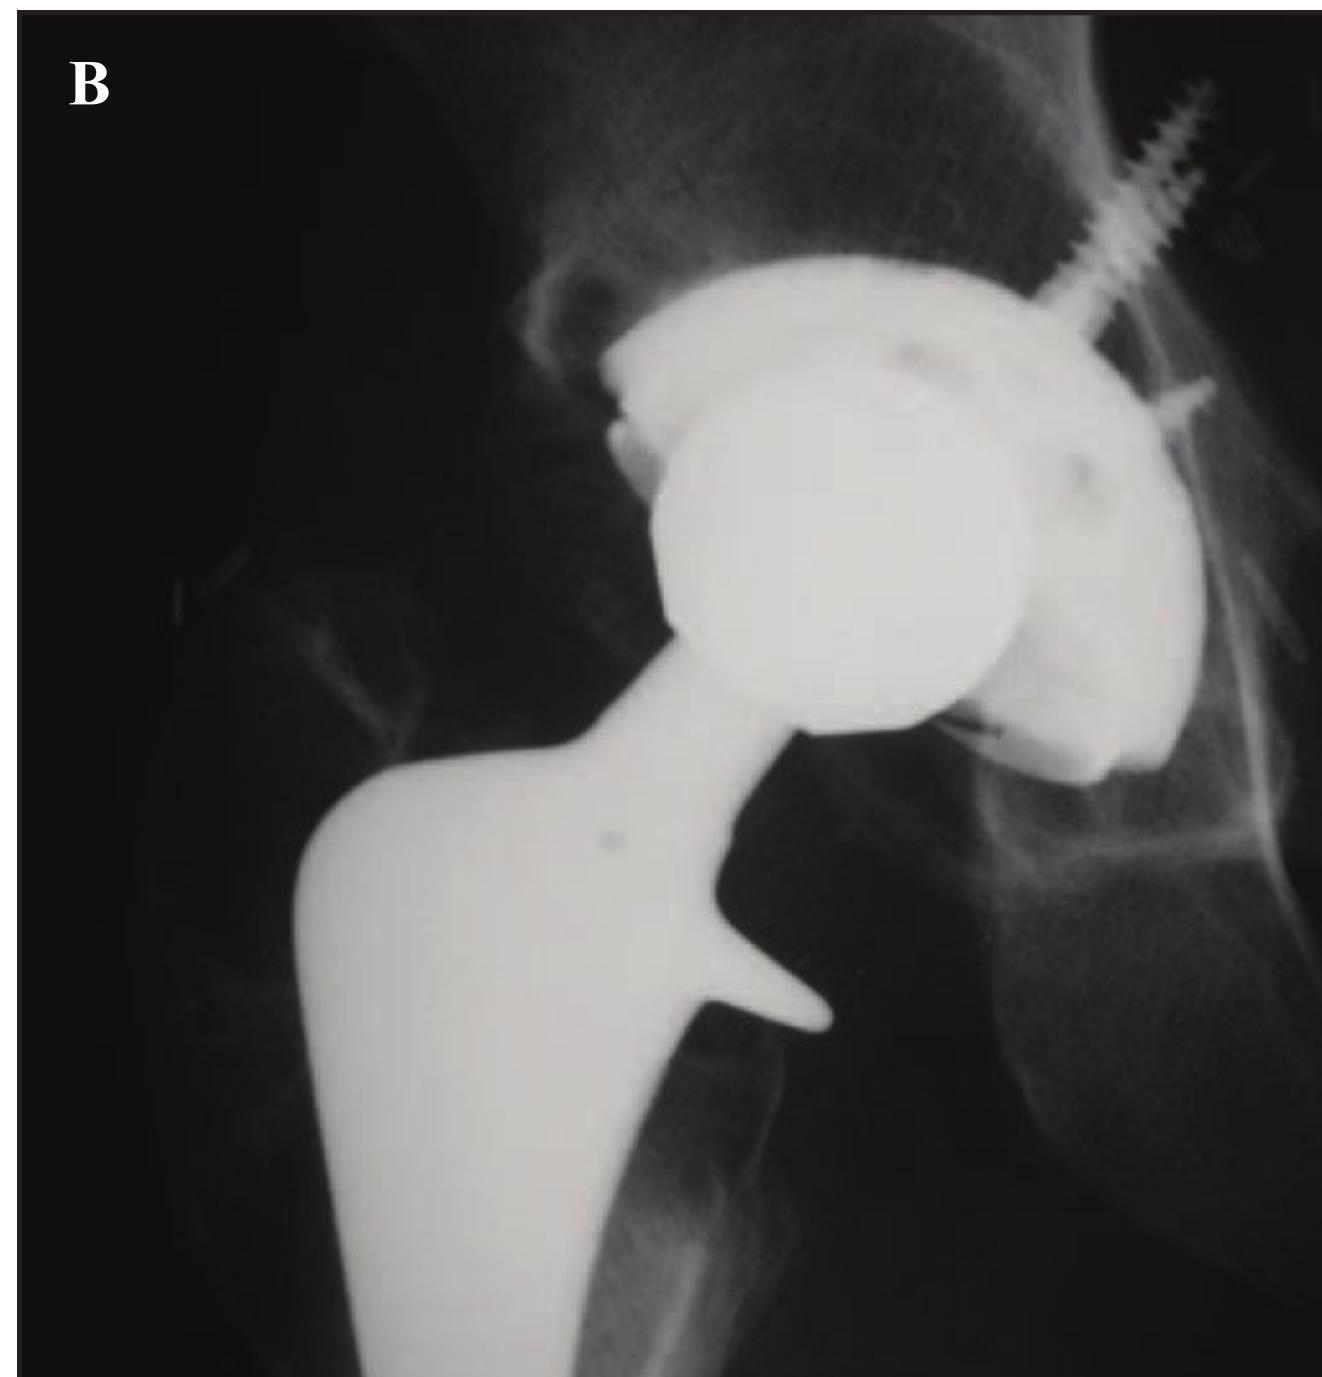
(A) AP radiograph of a right total hip arthroplasty taken 6 weeks postoperatively. (B) AP radiograph of the same patient taken 20 years later. Note the large area of osteolysis superior to the well-fixed acetabular component. (C) AP radiograph of the same patient 6 weeks after head/liner exchange, retention of the well-fixed acetabular shell and femoral stem, and bone grafting of the osteolytic lesion. Note the excellent reconstitution of the previously deficient acetabular bone.
